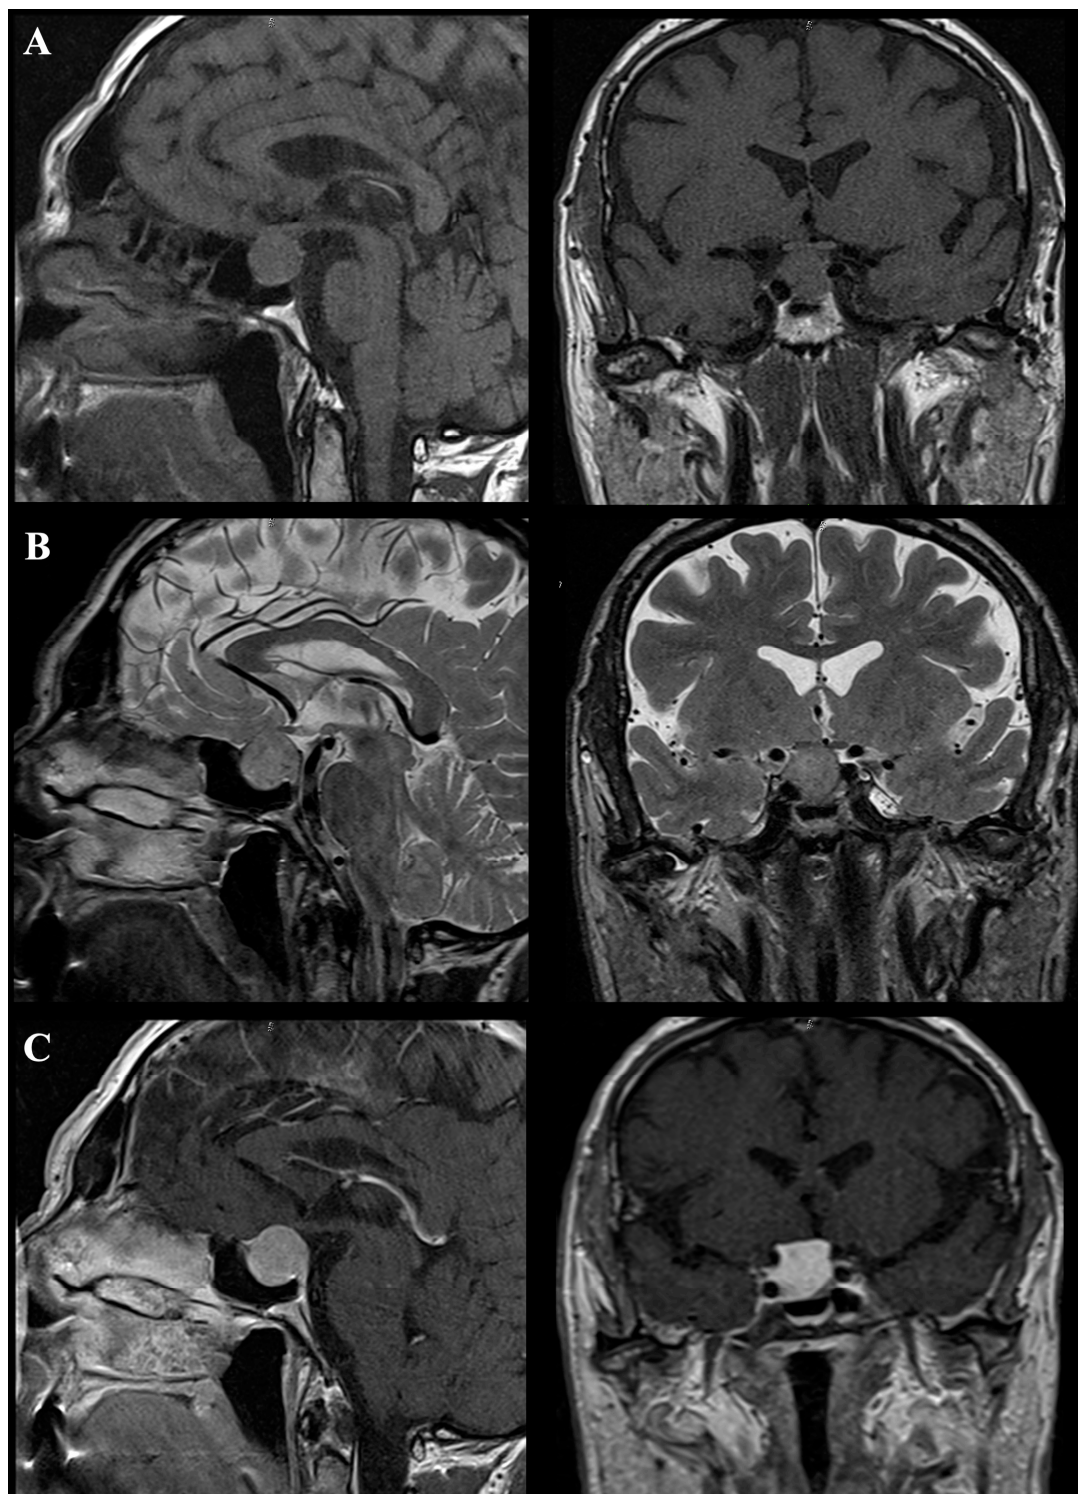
Preoperative magnetic resonance imaging of the sellar region. Sagittal and coronal T1-weighted images (A) and T2-weighted images (B) demonstrate an iso- to hypointense sellar mass with suprasellar extension. Contrast-enhanced sagittal and coronal T1-weighted images (C) reveal heterogeneous enhancement and parasellar extension with right cavernous sinus involvement (Knosp grade II).
